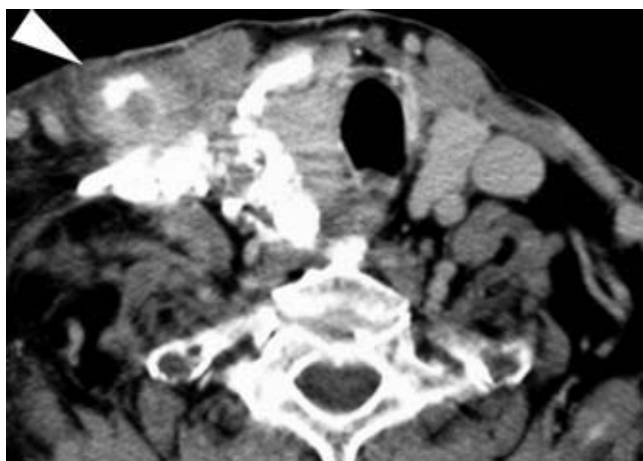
Neck computed tomography without contrast on the same patient as Figure 1-4 obtained from a previous admission. High-attenuation Thorotrast has dissected through the soft-tissue planes of the neck and was evident in the upper mediastinum (not shown). The patient's cutaneous sinus approximately at the level of this image is in a location marked by the arrowhead.
